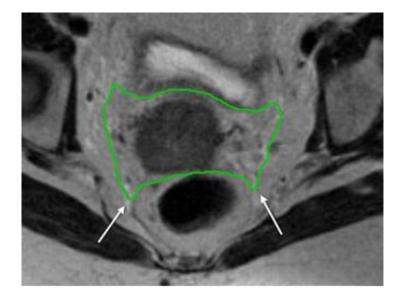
MRI (T2) A : Coronal, B : Axial, ; a :Superior limit (uterine arteries), b : lateral limit (medial edge iliac vessels region), c :posterior limit (mesorectum)
